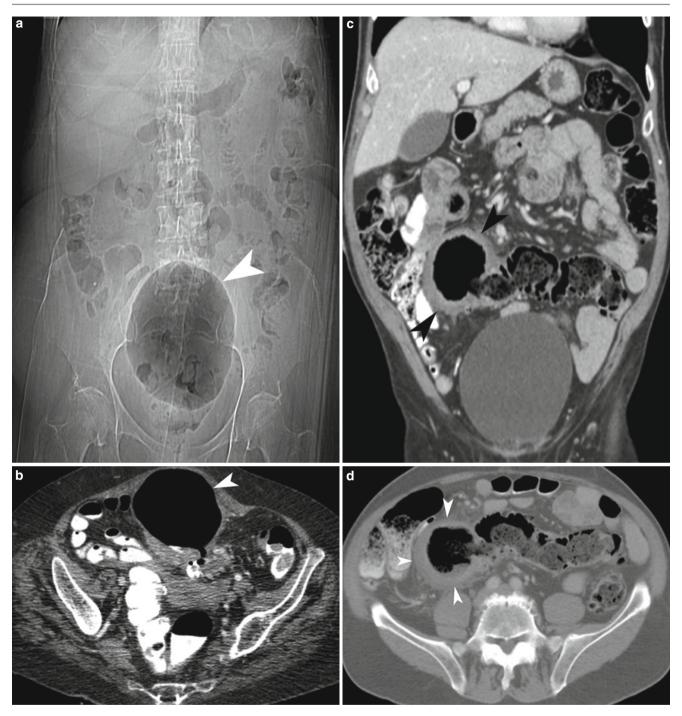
Giant sigmoid diverticulum. (a) Scout film of the abdomen demonstrates a 10-cm-diameter air-containing cavity in the pelvis which corresponds to a giant sigmoid diverticulum (*arrowheads*) in a patient with recurrent episodes of diverticulitis. (b) Contrast-enhanced CT scan study of the pelvis demonstrates a giant sigmoid diverticulum
